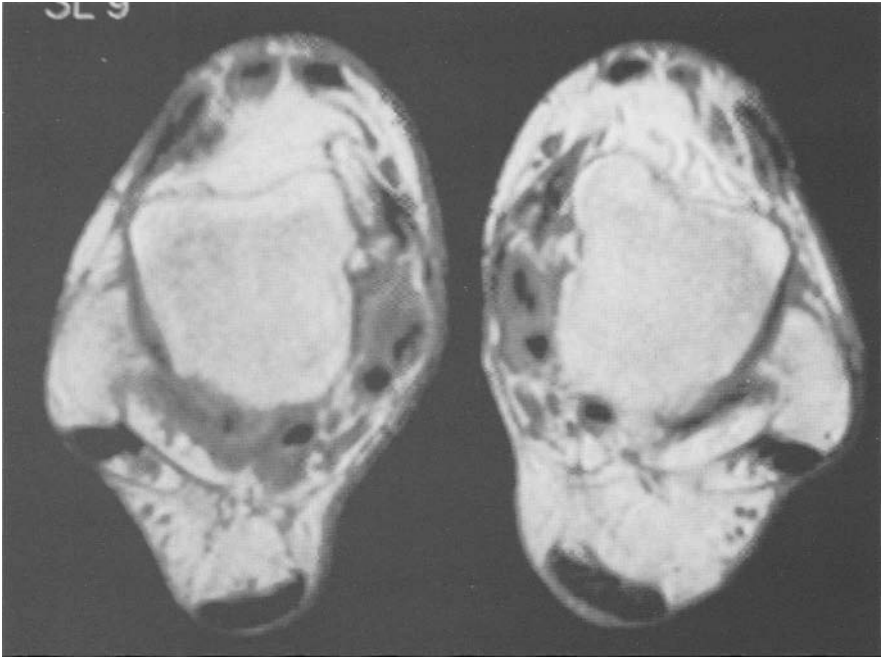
Same patient MRI, T1 (1999). Ptt bilateral stage 2 tendinopathy.
